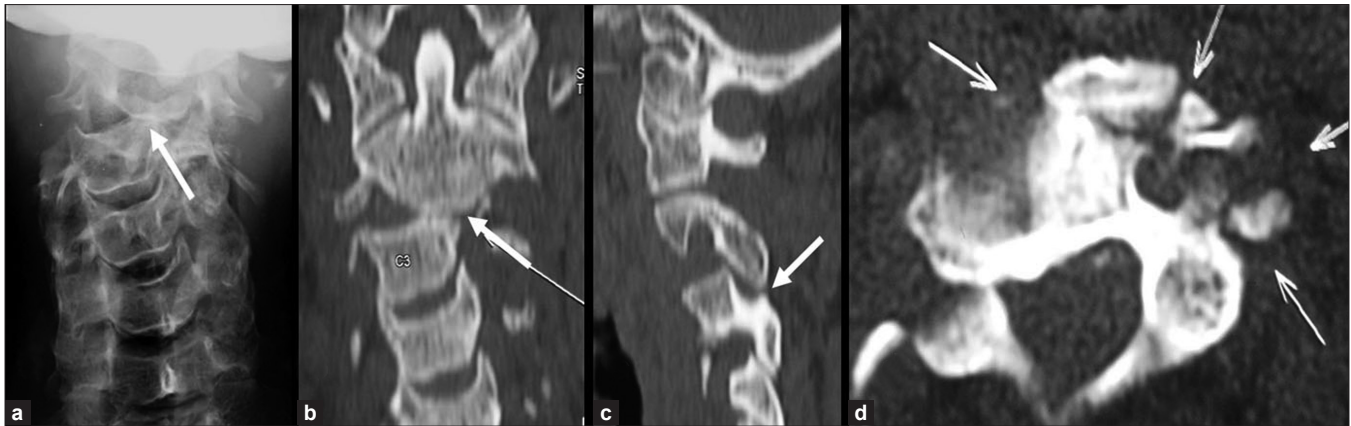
(a) Anteroposterior radiograph of the cervical spine showing significant lateral translation of C2 vertebral body over C3 (white arrow), (b) Coronal section of the CT scan showing near complete lateral translation of C2 over C3 body (white arrow), (c) Sagittal section of the CT scan showing dislocated C2-C3 facet joint on the right side, and (d) Axial section of CT scan showing fracture of the left transverse process (thick white arrows) and anterior part of C3 vertebral body (thin white arrow)
